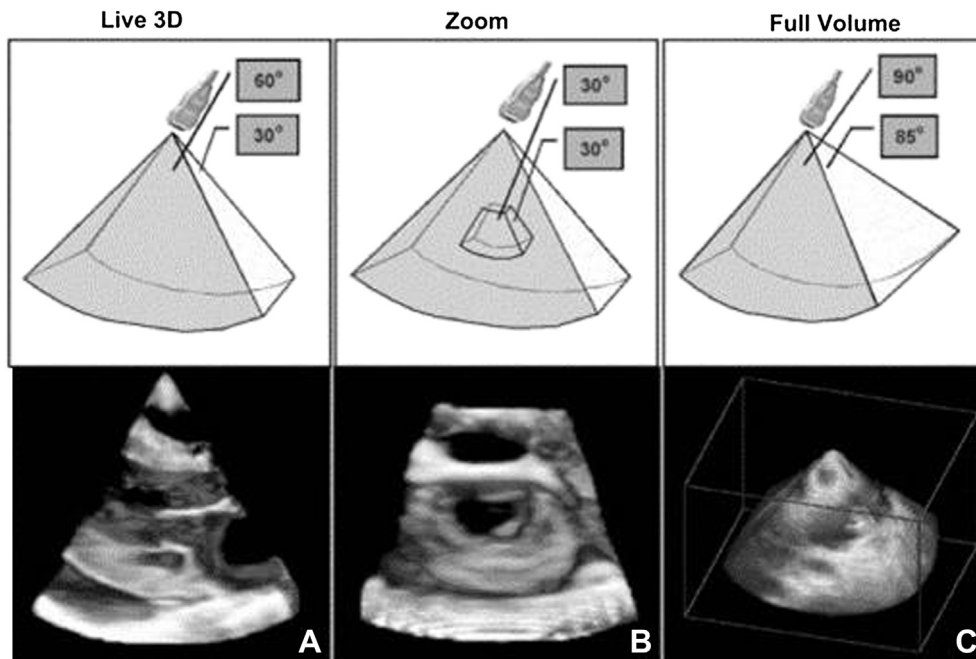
Modes of 3D echocardiography. J Am Coll Cardiol. November 21, 2006, 48 (10): 2053–2069.
